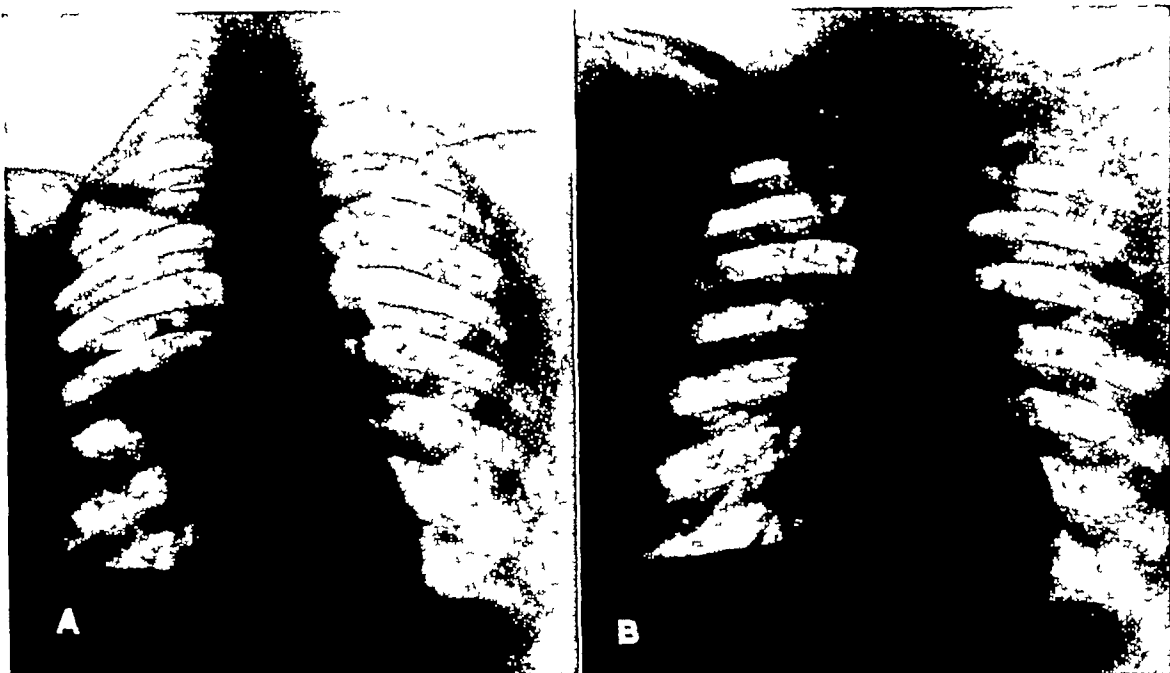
Case 2 A Roentgenogram showing a density in the right hilar region quite similar in appearance and characteristics to that in Figure 1
